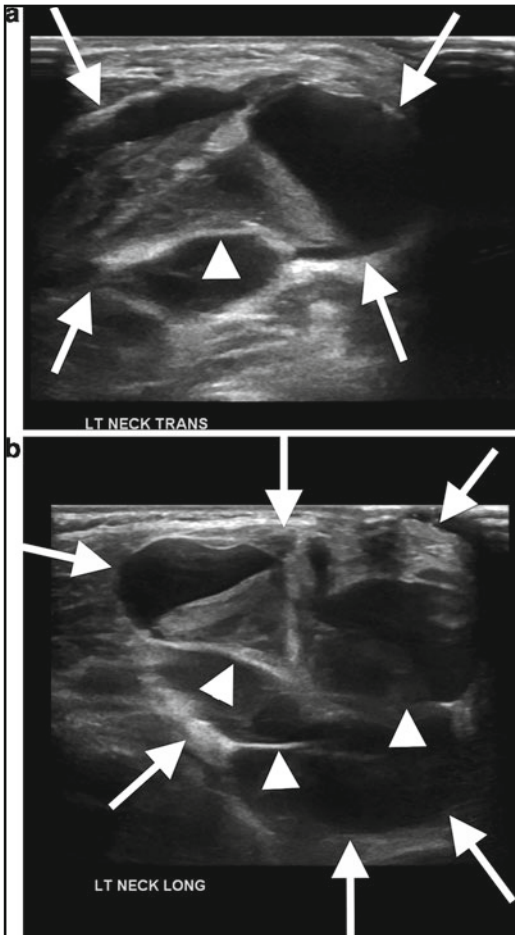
Lymphatic malformation. Transverse (a) and longitudinal (b) neck ultrasound in a 3-year-old boy with new swelling near the thyroid gland reveals a very complex, transspatial, multiloculated fluid collection (*white arrows, a and b*) extending from the region of the thyroid (not shown) into the left lateral neck. Note the presence of thin septations (*arrowheads, a and b*), typical of macrocystic lymphatic malformations. Two axial fluid-sensitive sequence MR images (c) better show the internal characteristics of this complex cystic lesion (*yellow arrows*) as well as its relationship regional structures, including the thyroid gland (*small white arrows, upper image*). Again, note numerous thin septations (*arrowheads*) and fluid–fluid levels (*large white arrows*) from prior internal hemorrhage. Two contrast-enhanced MR images (d) show that the lesion (*yellow arrows*) does not enhance, supporting the diagnosis of lymphatic
